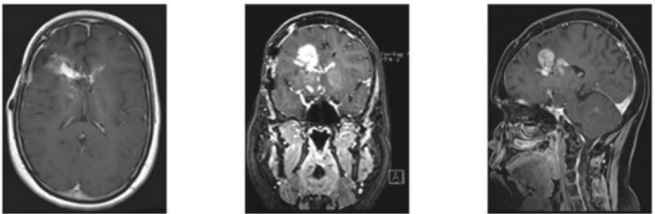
Vignette of case 2 with specialty-specific answers on the question ‘Would you recommend a re-resection in this case?’ and underlying considerations. MRI images shown are T1-weighted images after contrast administration.
